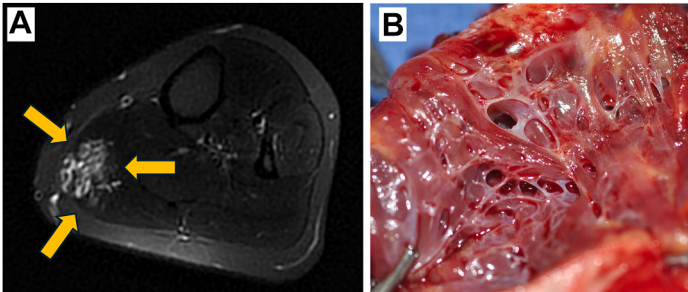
(A, B) (A) T2-weighted MRI of a spongiform venous malformation (VM; orange arrows). (B) Per-operative view of a spongiform VM.
